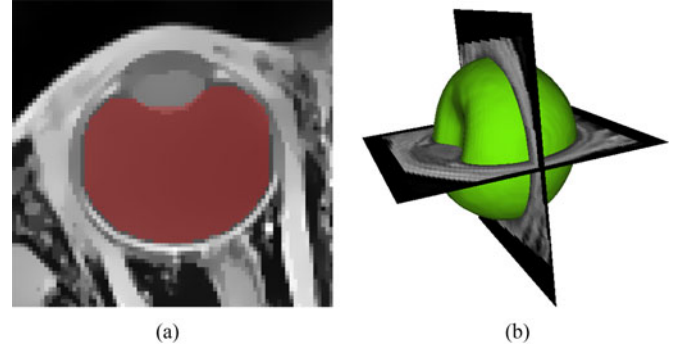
(a) MRI slice with the segmentation labels superimposed. The red pixels designate the *inside* label. (b) Transition between *inside* and *outside* labels is used to define the surface of the vitreous humor (green). Two corresponding MRI slices are intersected with the surface. (a) Graph cut segmentation. (b) Segmentation.
